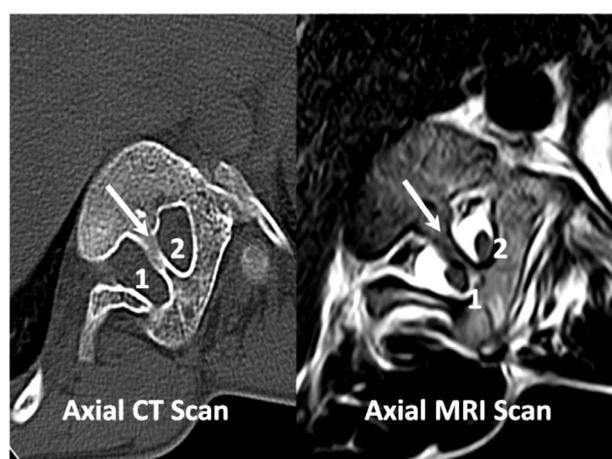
Axial CT & Axial MRI showing calcified bar splitting the spinal cord into two.
